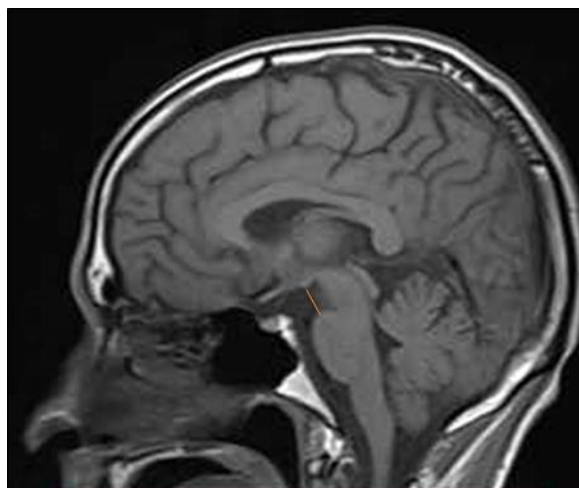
T1-sagittal section of MRI brain showing the measurement of the ponto-mamillary distance
